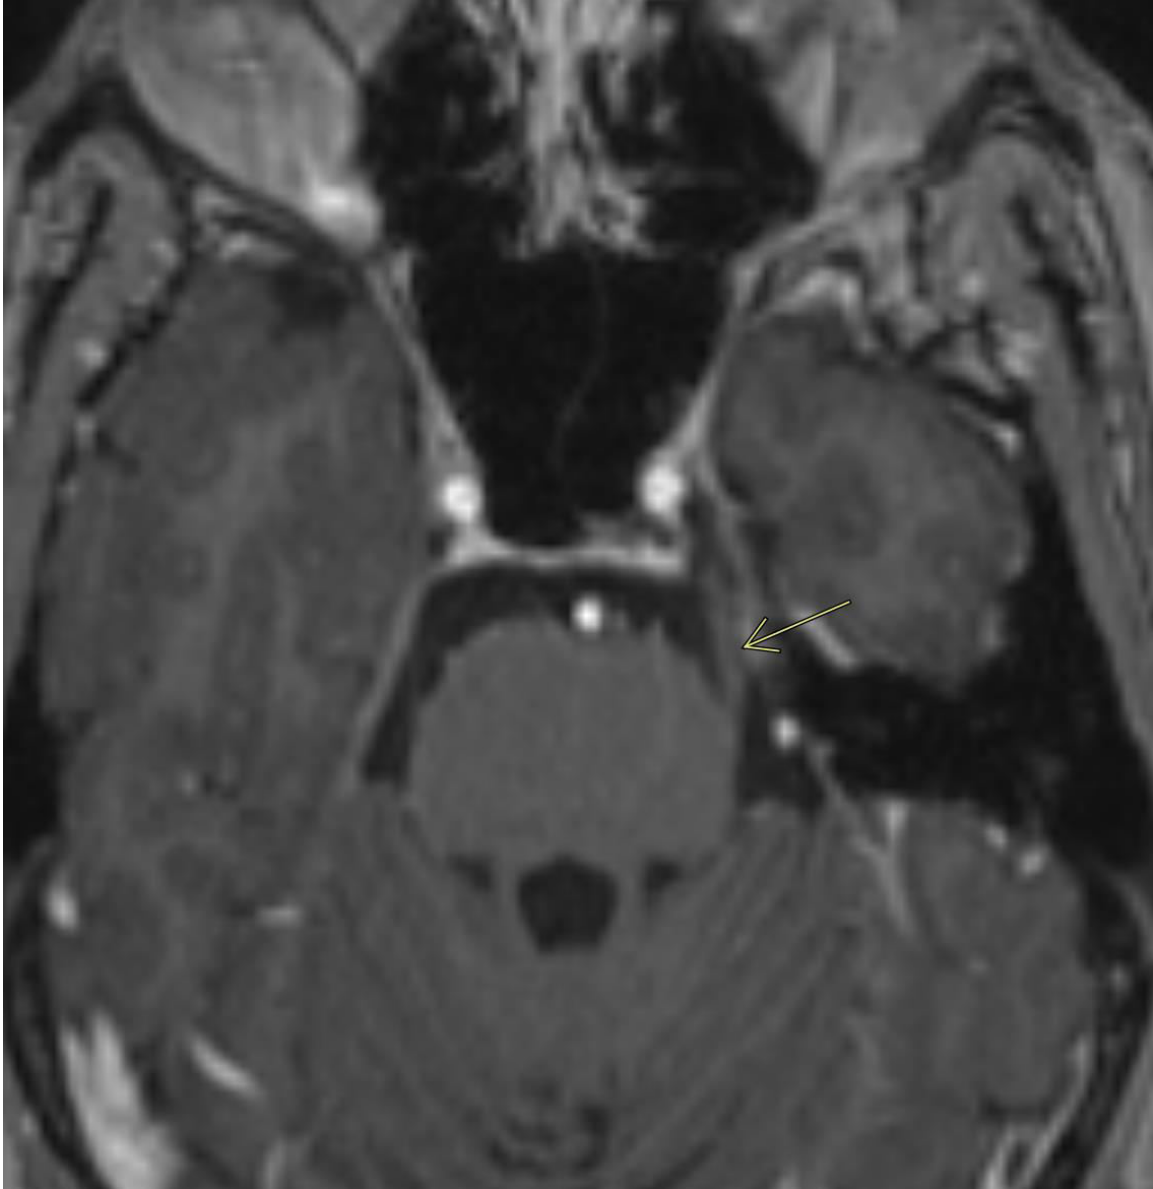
Follow-up brain MRI showed interval resolution of the previously noted left trigeminal nerve thickening
